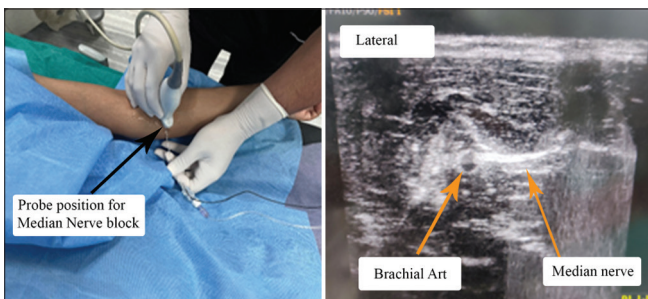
Probe position and corresponding sonographic view of median nerve block. The injection site is slightly below the elbow joint where the nerve can be visualized medial to the brachial artery. The ultrasound probe was placed just distal to the elbow. The needle was inserted in-plane from medial to lateral and 6 mL of the solution was deposited.
